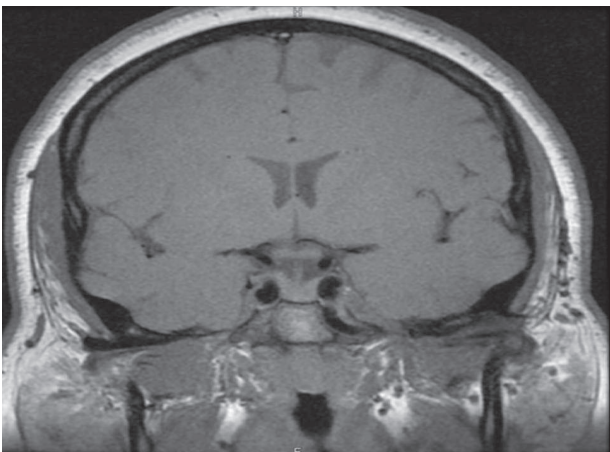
(B): MRI Pituitary (Coronal View) Revealing Stalk Deviation to Right Side
